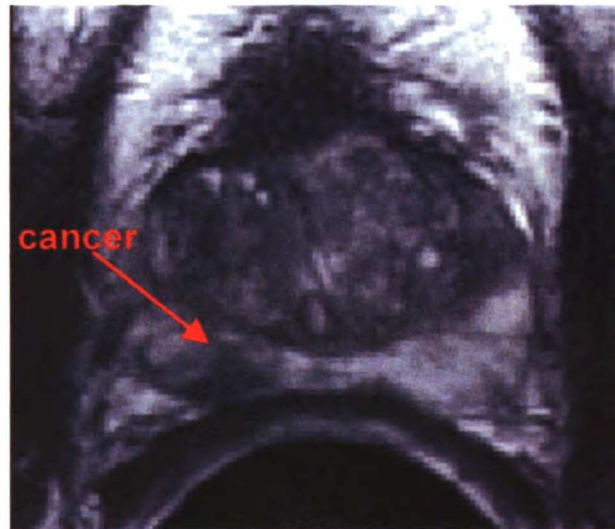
Axial T2-weighted MRI of the prostate. Regions of prostate cancer demonstrate reduced signal intensity compared to benign prostate peripheral zone.
